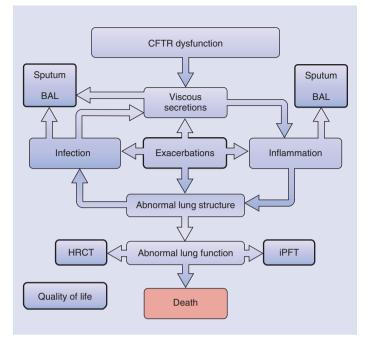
Methods to monitor cystic-fibrosis-related lung disease for clinical management. BAL, bronchoalveolar lavage; CFTR, cystic fibrosis transmembrane conductance regulator; HRCT, high-resolution computed tomography; iPFT, infant pulmonary function tests.
